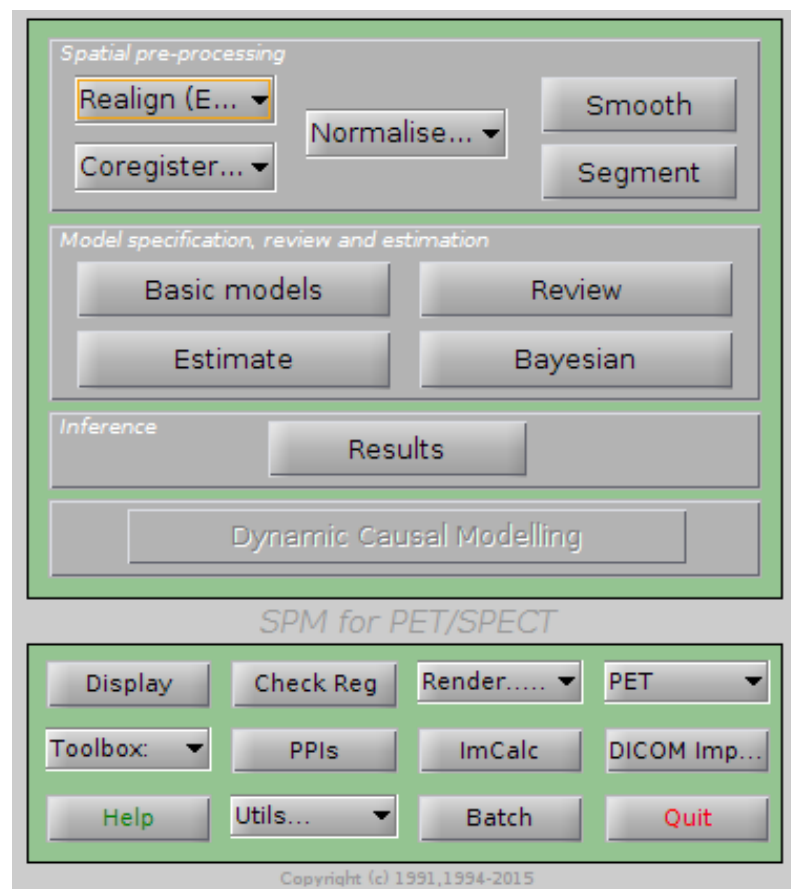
The SPM12 graphical user interface (GUI), employed here to carry out pre-processing on PET and MRI data.
